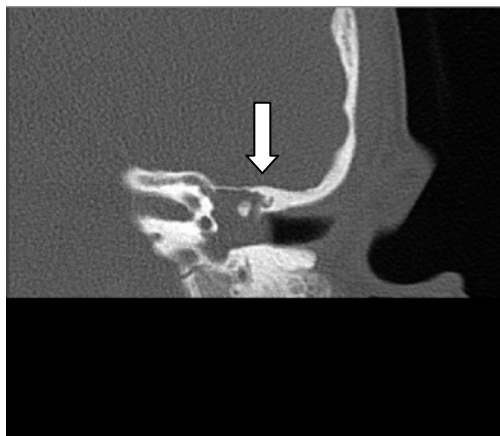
High resolution CT of temporal bone showed evidence of cholesteatoma with erosion of scutum and ossicles (arrow)
